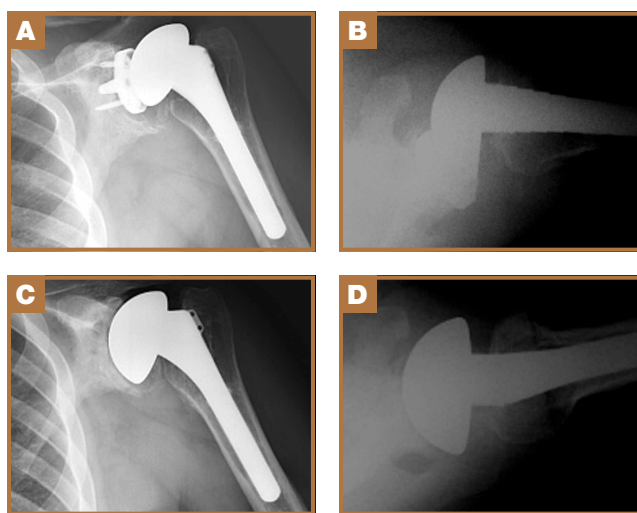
(A, B) Preoperative anteroposterior and axillary radiographs identifying migration of loose metal-backed glenoid. (C, D) Six months after surgery to treat severe central deficiency, radiographs show graft incorporation with mild medialization.
